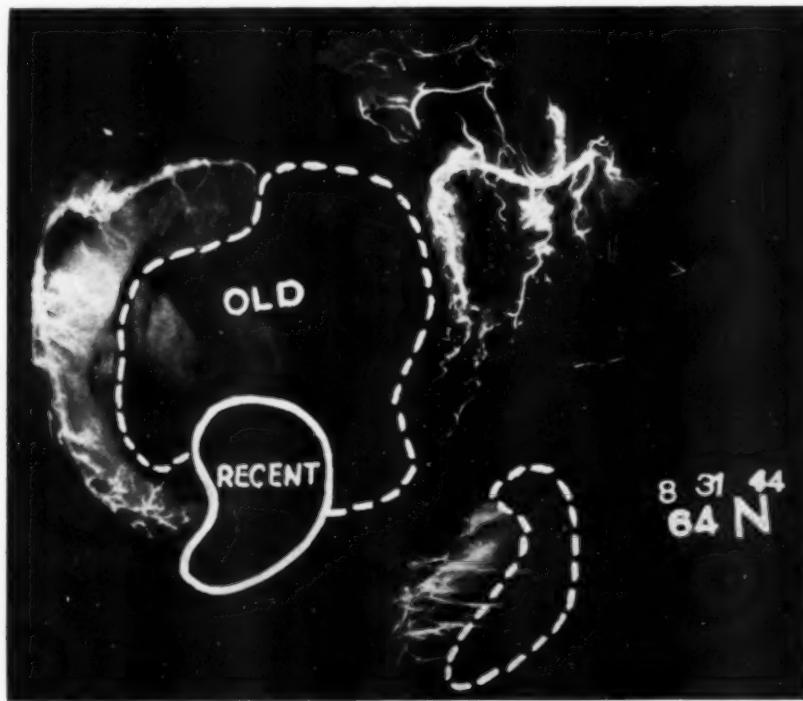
Roentgenogram of injected heart in Case 60 with recent anterolateral infarct indicated by solid lines and old posterior infarct by broken lines.
